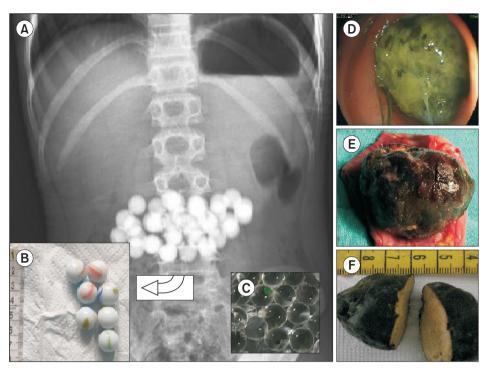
(A, B) X-ray and post-exit images of ingested glass beads. (C) Superabsorbent water balls. (D) A large superabsorbent object at endoscopy and (E, F) after surgery.
